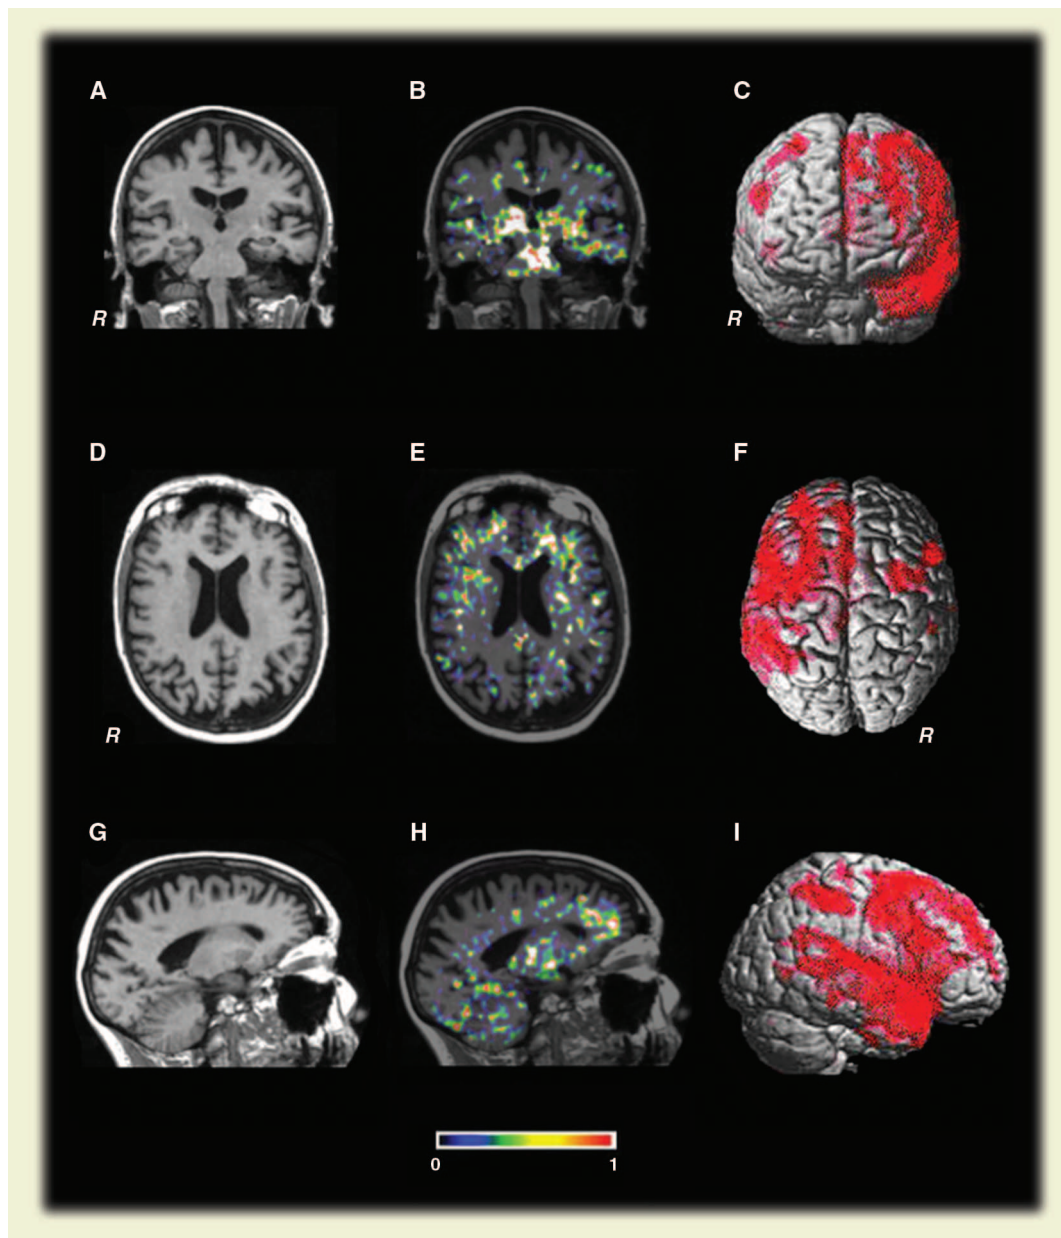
[^{11}C](R)-PK11195 positron emission tomography images of a patient with predominantly left-hemispheric fronto-temporal lobar dementia (age, 69 years; disease duration, 3 years) (B, E, H) coregistered to the same patient’s magnetic resonance imaging scans (A, D, G). The red in the volume-render magnetic resonance imaging scans (C, F, I) indicates areas of substantial atrophy. These areas overlap with the regional pattern of increased [^{11}C](R)-PK11195 signal. At the bottom of the image, the color bar denotes [^{11}C](R)-PK11195 binding potential values between 0 and 1. The images are shown in radiological convention; that is, the left side of the image is the right of the patient, indicated by R. (F) Top-down view onto the cortex with the right side of the image also being the right of the patient. (G and H) Sagittal sections through the left hemisphere. [Courtesy of R. B. Banati, Sydney (54)]
